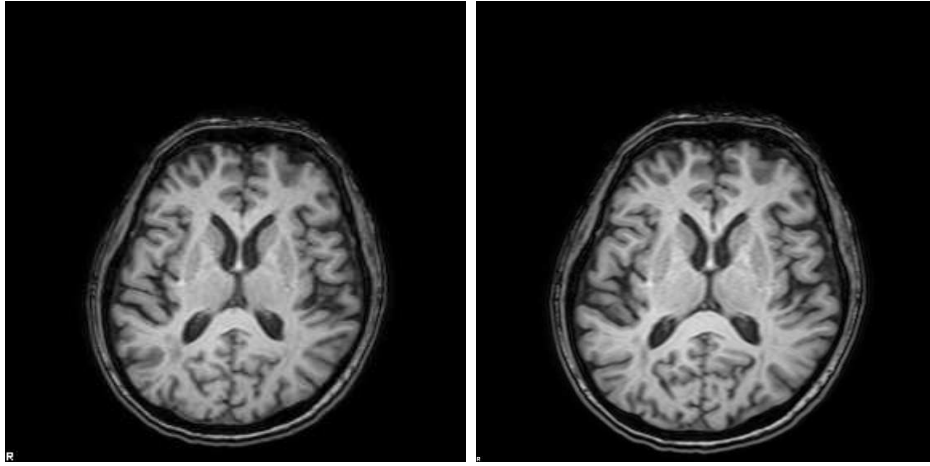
Spatially Transformed MPRAGE Image. The image on the left is an MPRAGE image. The image on the right is the MPRAGE image spatial transformed to be registered to the FLAIR image.
